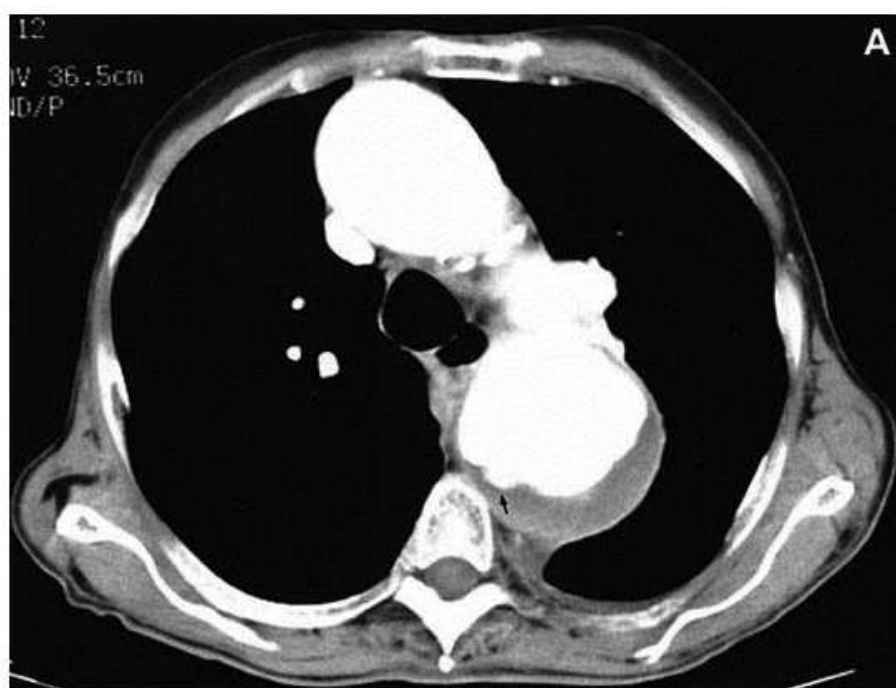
Computed tomography demonstrating a penetrating aortic ulcer as indicated by the black arrow (from Reference 18 – permission granted).
